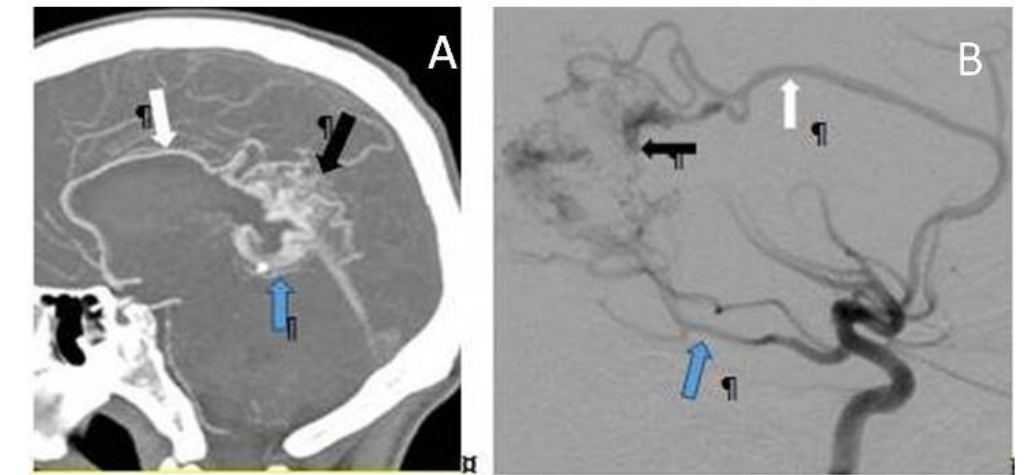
(A) Sagittal CTA MIP image shows the left pericallosal artery (white arrow) supplying the nidus (black arrow) located in the left parietal lobe. Vein of Galen (blue arrow) drained the nidus which measured 4.1cm.
